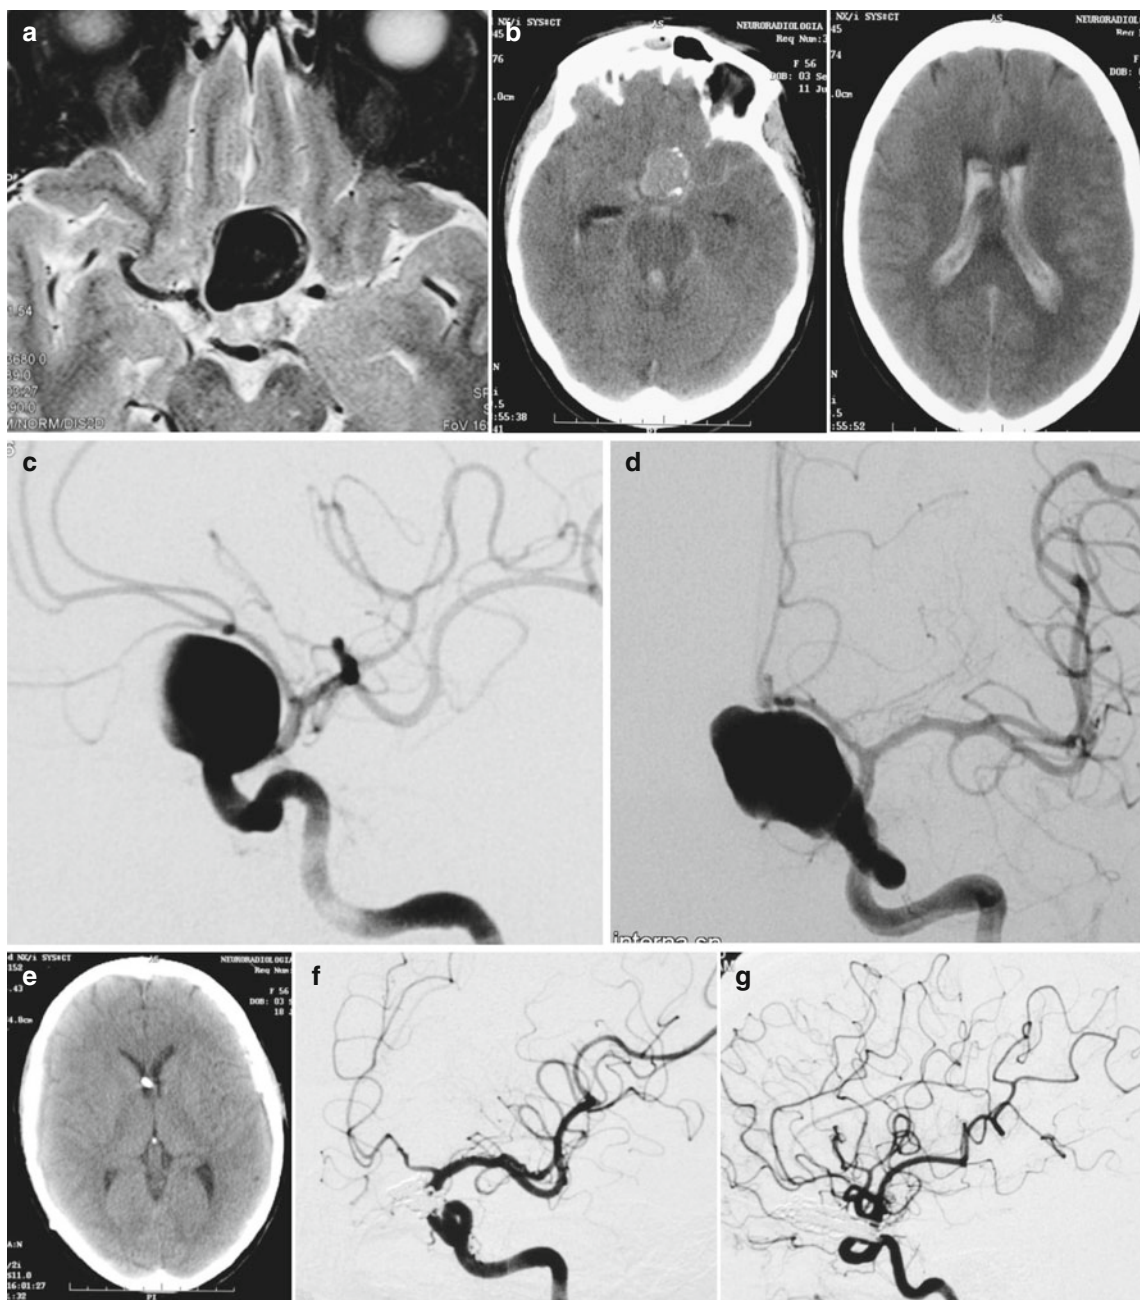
(a) MRI of a 56-year-old woman with marked decrease of vision in her left eye; (b) severe subarachnoid and ventricular hemorrhage a few hours after MRI; Glasgow Coma Score 4 on admission; (c, d) angiography showing a giant left paraclinoid aneurysm
